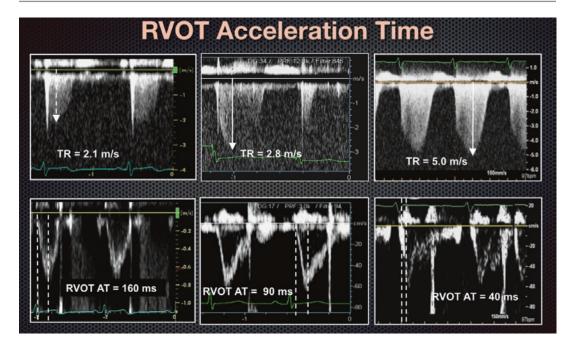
Pulsed wave Doppler from the RV outflow track from three different patients demonstrating the acceleration time in relation to the maximal TR jet velocity. Note that as the TR velocity is higher, the AT becomes
